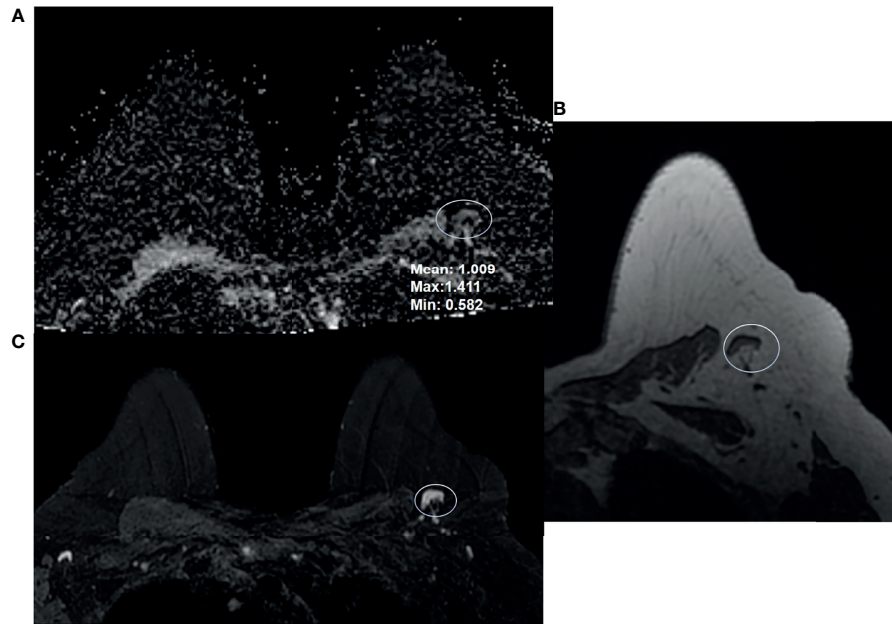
68-year-old woman presented for high-risk screening breast MRI exam. She had a family history of cancer, and was BRCA1 and ATM positive. Breast MRI shows a benign appearing left axillary level 1 lymph node: (A) ADC, (B) T1-weighted non-fat saturated, and (C) T2-weighted fat saturated axial sequences.
